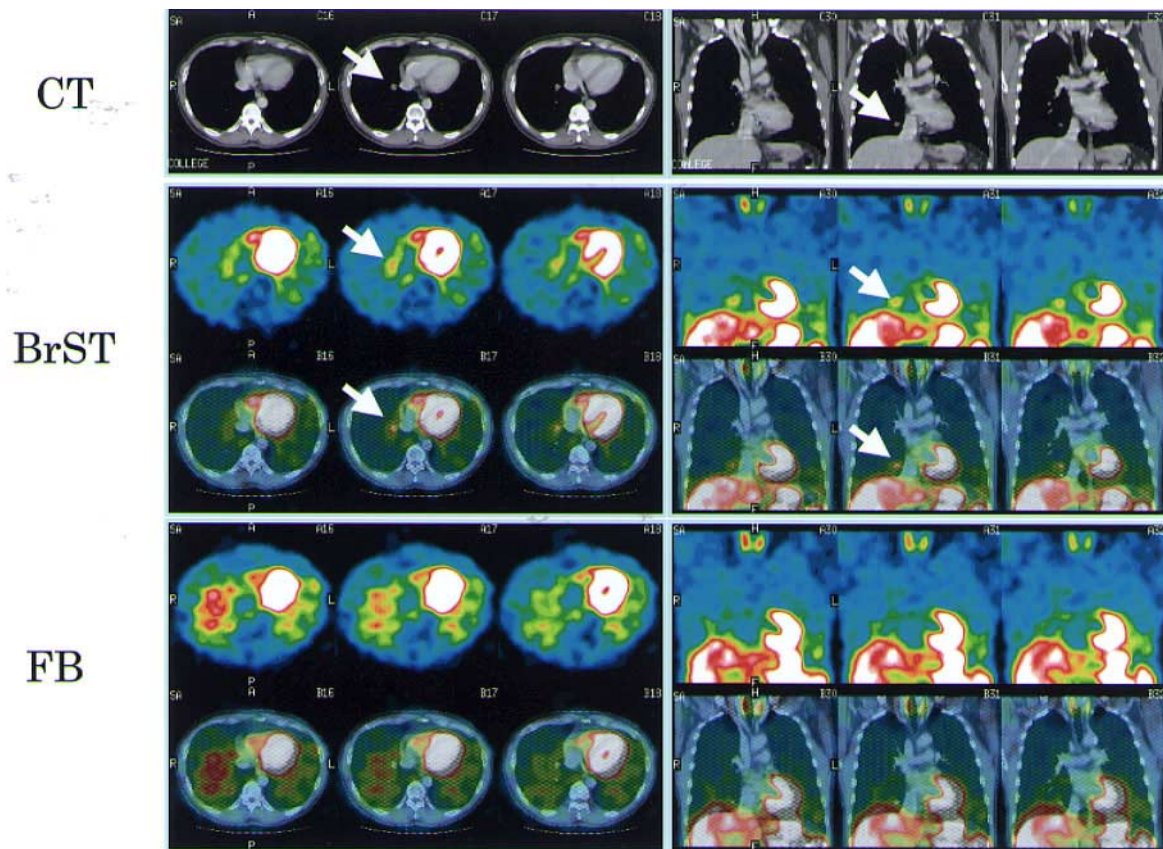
Case 5. Chest CT scanning showed an abnormal shadow measuring 12×10 mm in the right lower lobe. The BrST method of ^{201}Tl SPECT demonstrated abnormal accumulation corresponding to the lesion on the early images, whereas the FB method of ^{201}Tl SPECT did not demonstrate any accumulation. This shadow was a non-small cell lung carcinoma.
